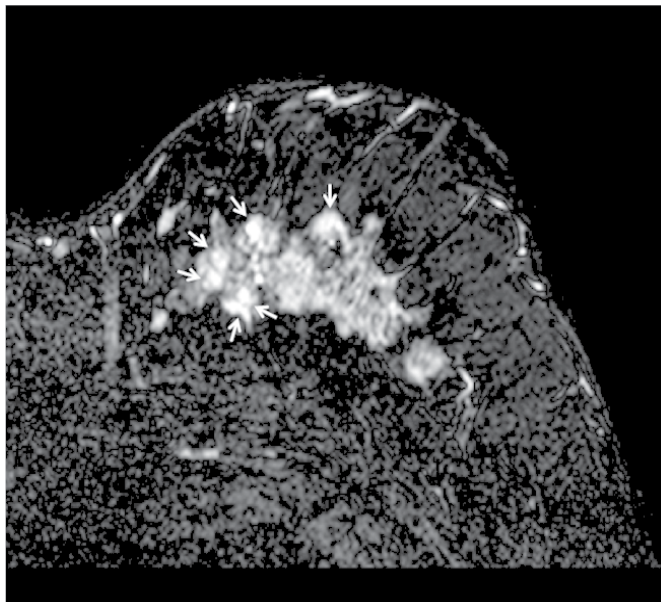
Fat-saturated T2 weighted image of HR-MRI; Multiple nodular high signal intensities are seen on the mass (arrows). These high signal intensities might reflect the secretory material of the secretory carcinoma.
